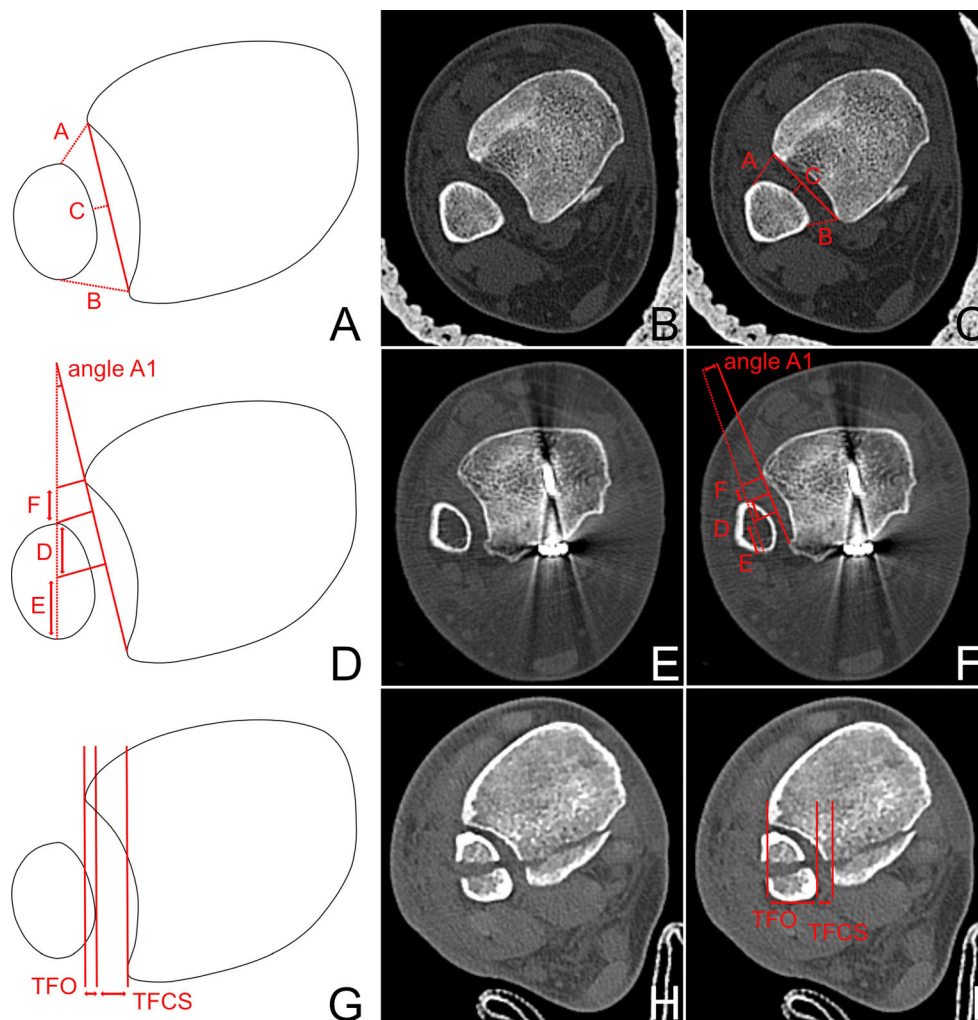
Frequently used measurement methods to assess the distal tibio-fibular syndesmosis using computed tomography (CT) scans. Measurements were performed 1 cm above the distal tibial plafond. a Measurement of the tibio-fibular width anterior (A), middle (C) and posterior (B). b 35-year old patient with an acute syndesmosis instability following a high fibular and posterior malleolar fracture. The syndesmosis injury was not addressed on the primary surgery. c Measurement of the tibio-fibular width. d Measurement of the antero-posterior translation (D, E, F) and the rotation (angle A1) of the distal fibula. e 47-year old patient
